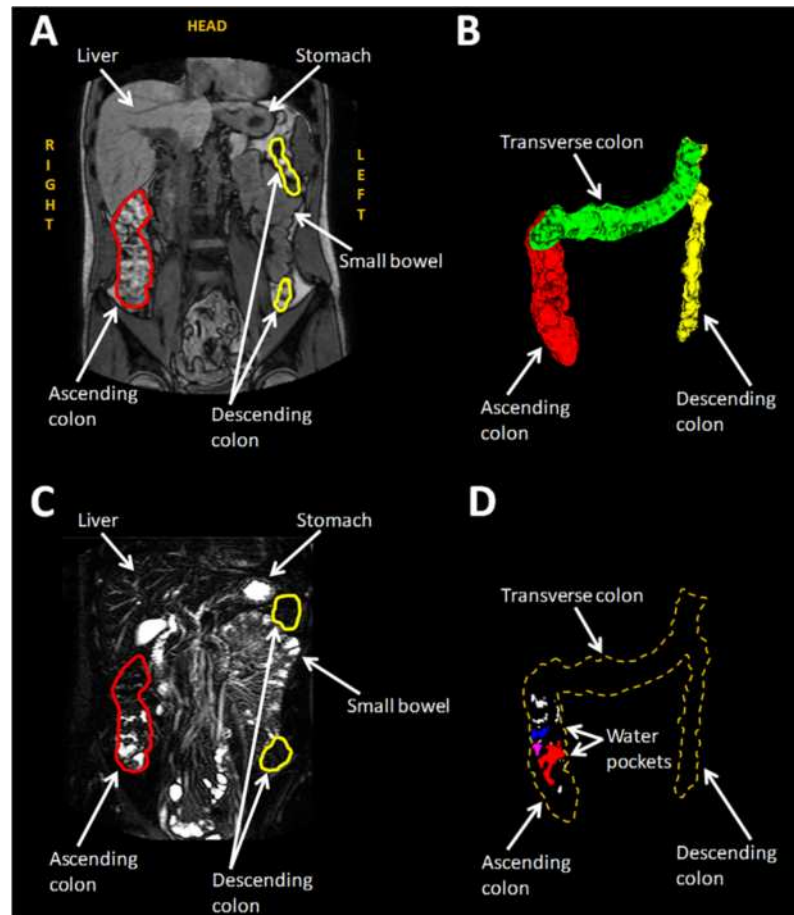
(A) MRI bowel image. (B) 3-D reconstruction of the bowel. Red, green and yellow stand for ascending, transverse and descending colon respectively. (C) Highly T2 weighted image with the same angle of (A). Unbound liquid appears white whereas bound and less mobile liquid seem darker. (D) Unbound liquid of the colon. Taken from (37).
